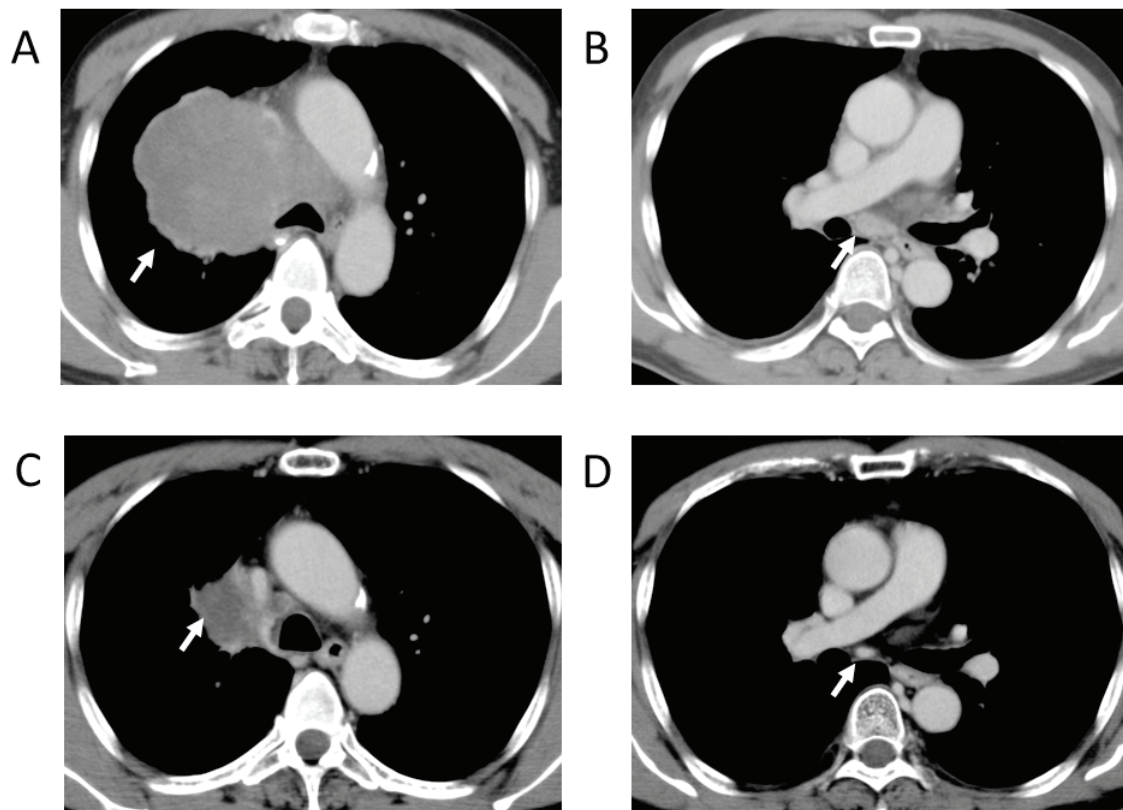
Computed tomography scan prior to and following chemotherapy. (A) A large tumor (diameter, 90 mm) with low blood flow was identified in the hilum of the right lung (arrow). The tumor infiltrated into the superior vena cava. (B) An enlarged lymph node (diameter, 12 mm) was detected at the bronchial bifurcation (arrow). After 3 courses of therapy, the sizes of (C) the tumor in the right lung and (D) the lymph node at the bronchial bifurcation were reduced (arrows).
